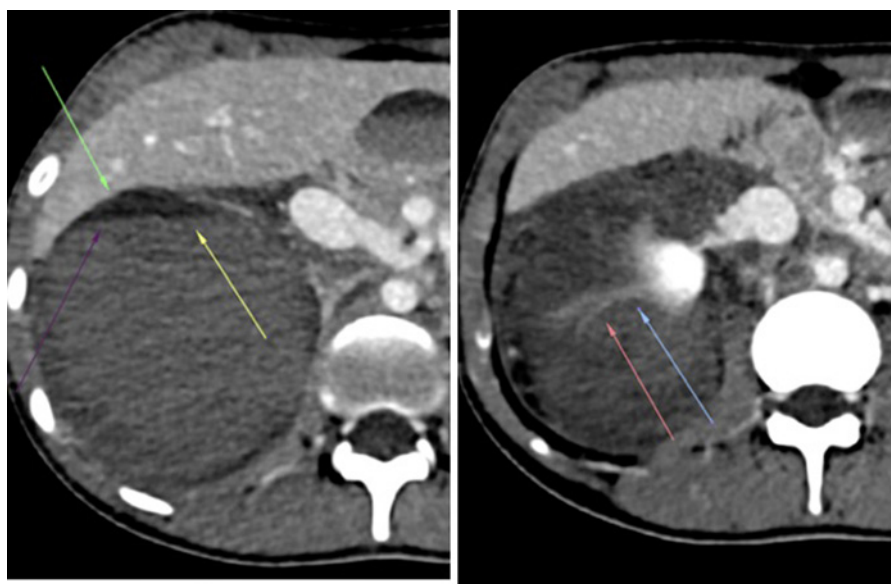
Axial computed tomography images without (left) and with (right) contrast, with extravasation of contrast causing hematoma.
